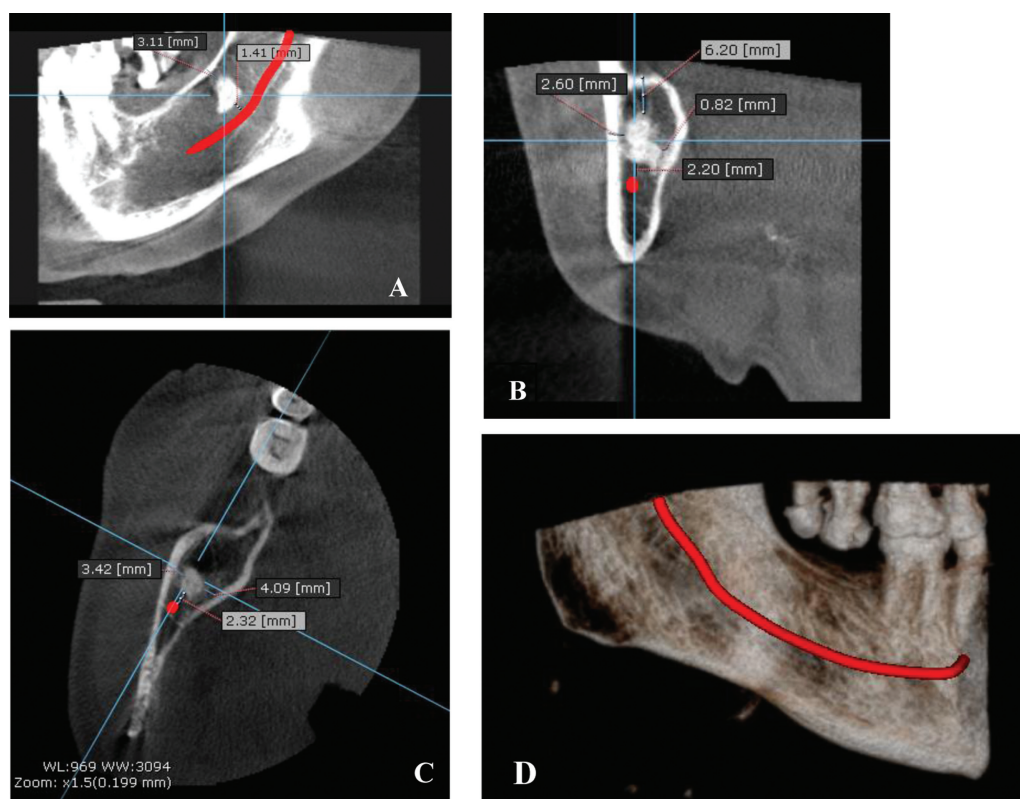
Cone beam computed tomography (CBCT) result region 48. (A) Sagittal view. (B) Coronal view. (C) Axial view. (D) Three-dimensional (3D) reconstruction.
